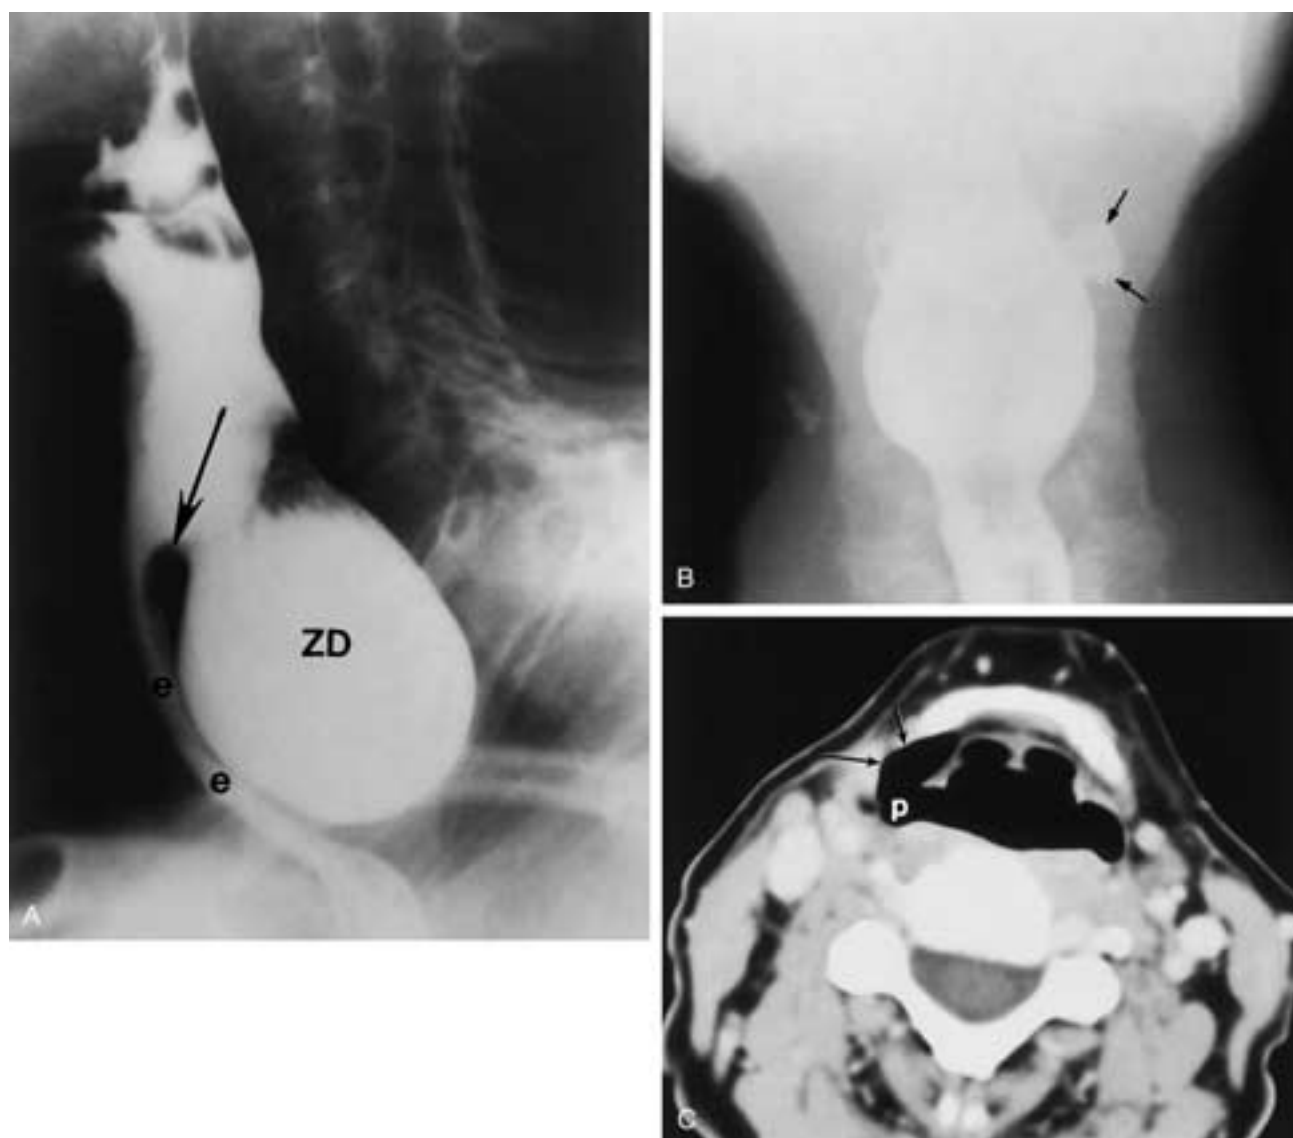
A, Oblique view of a barium swallow shows a large Zenker's diverticulum (ZD) extending from the hypopharynx above the cricopharyngeus muscle (*arrow*) and extending down into the upper chest behind the cervical esophagus (*e*). B, Frontal view of a barium swallow shows a small pharyngocele (*arrows*) arising from the left pyriform sinus. C, Axial CT scan shows an air-filled pharyngocele (*arrows*) arising from the right pyriform sinus (*p*).
